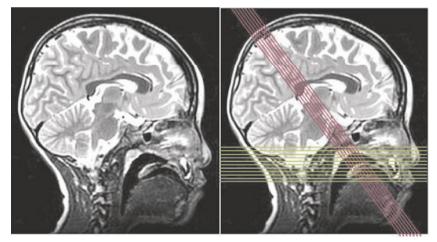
Planes of MRI scans. The image on the left is a midsagittal slice of a 6-year-old boy with right complete cleft lip and palate and VPI following palatal repair. In addition to a multislice sagittal scan covering the whole head, there were a transverse scan covering the whole velopharyngeal mechanism and an oblique scan covering the entire course of the levator muscle sling. The orientations of the transverse and oblique scans are demonstrated in green and red lines in the image on the right
